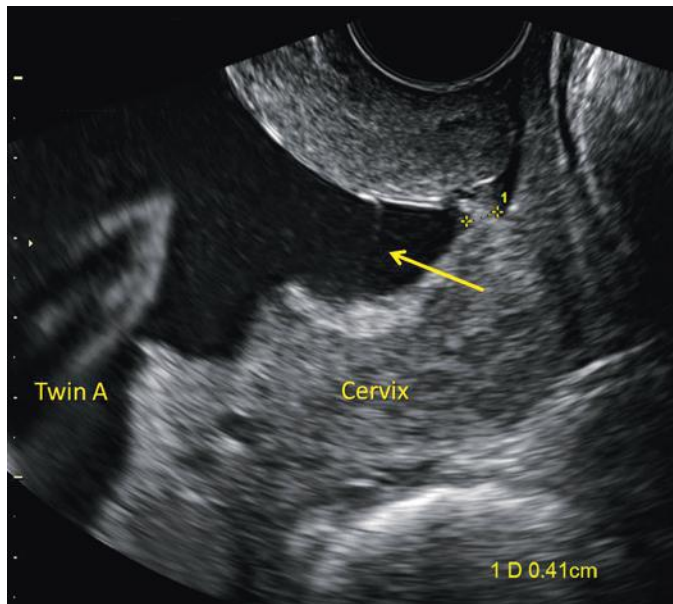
Transvaginal ultrasound image showing a funneled short cervix, measuring 0.41 cm in length, in a monozygotic diamniotic twin gestation with oligohydramnios-polyhydramnios sequence. A portion of the amniotic membrane of the presenting twin A (arrow) is seen within the dilated cervical canal.
